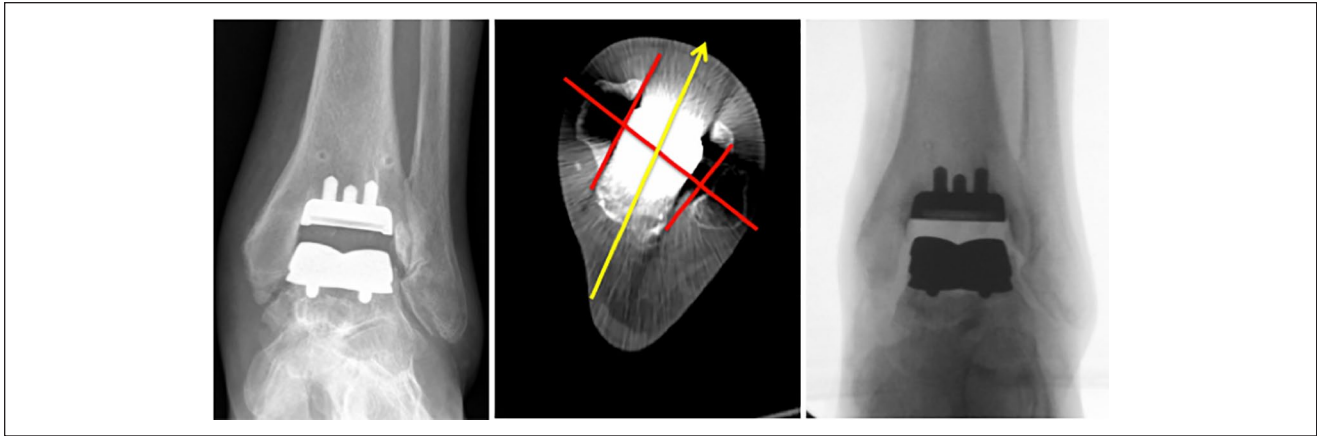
Case example of a 68-year-old female patient with medial gutter impingement postoperatively after placement of PROPHECY INFINITY total ankle replacement (left image). The middle image (axial computed tomography scan postoperatively) demonstrates the axial positioning of the talar implant (arrow), which is 15 degrees internally rotated relative to the transmalleolar axis (line bisecting both malleoli). The right image shows the postoperative result after medial gutter debridement, interposition arthroplasty, and transosseous sutures.
